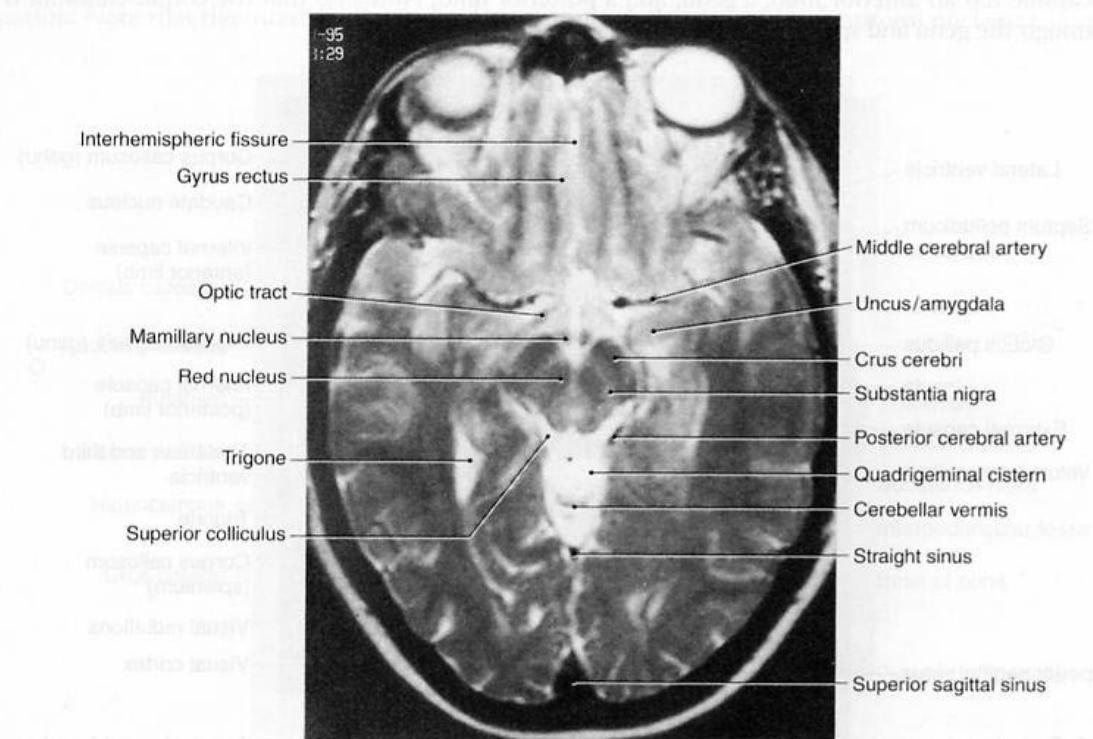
Axial magnetic resonance imaging (MRI) section at the level of the midbrain and mamillary bodies. Because of the high iron content, the red nuclei, mamillary bodies, and substantia nigra show a reduced MRI signal in T2-weighted images. Flowing blood in the cerebral vessels stands out as a signal void. Cerebrospinal fluid produces a strong signal in the ventricles and cisterns.
